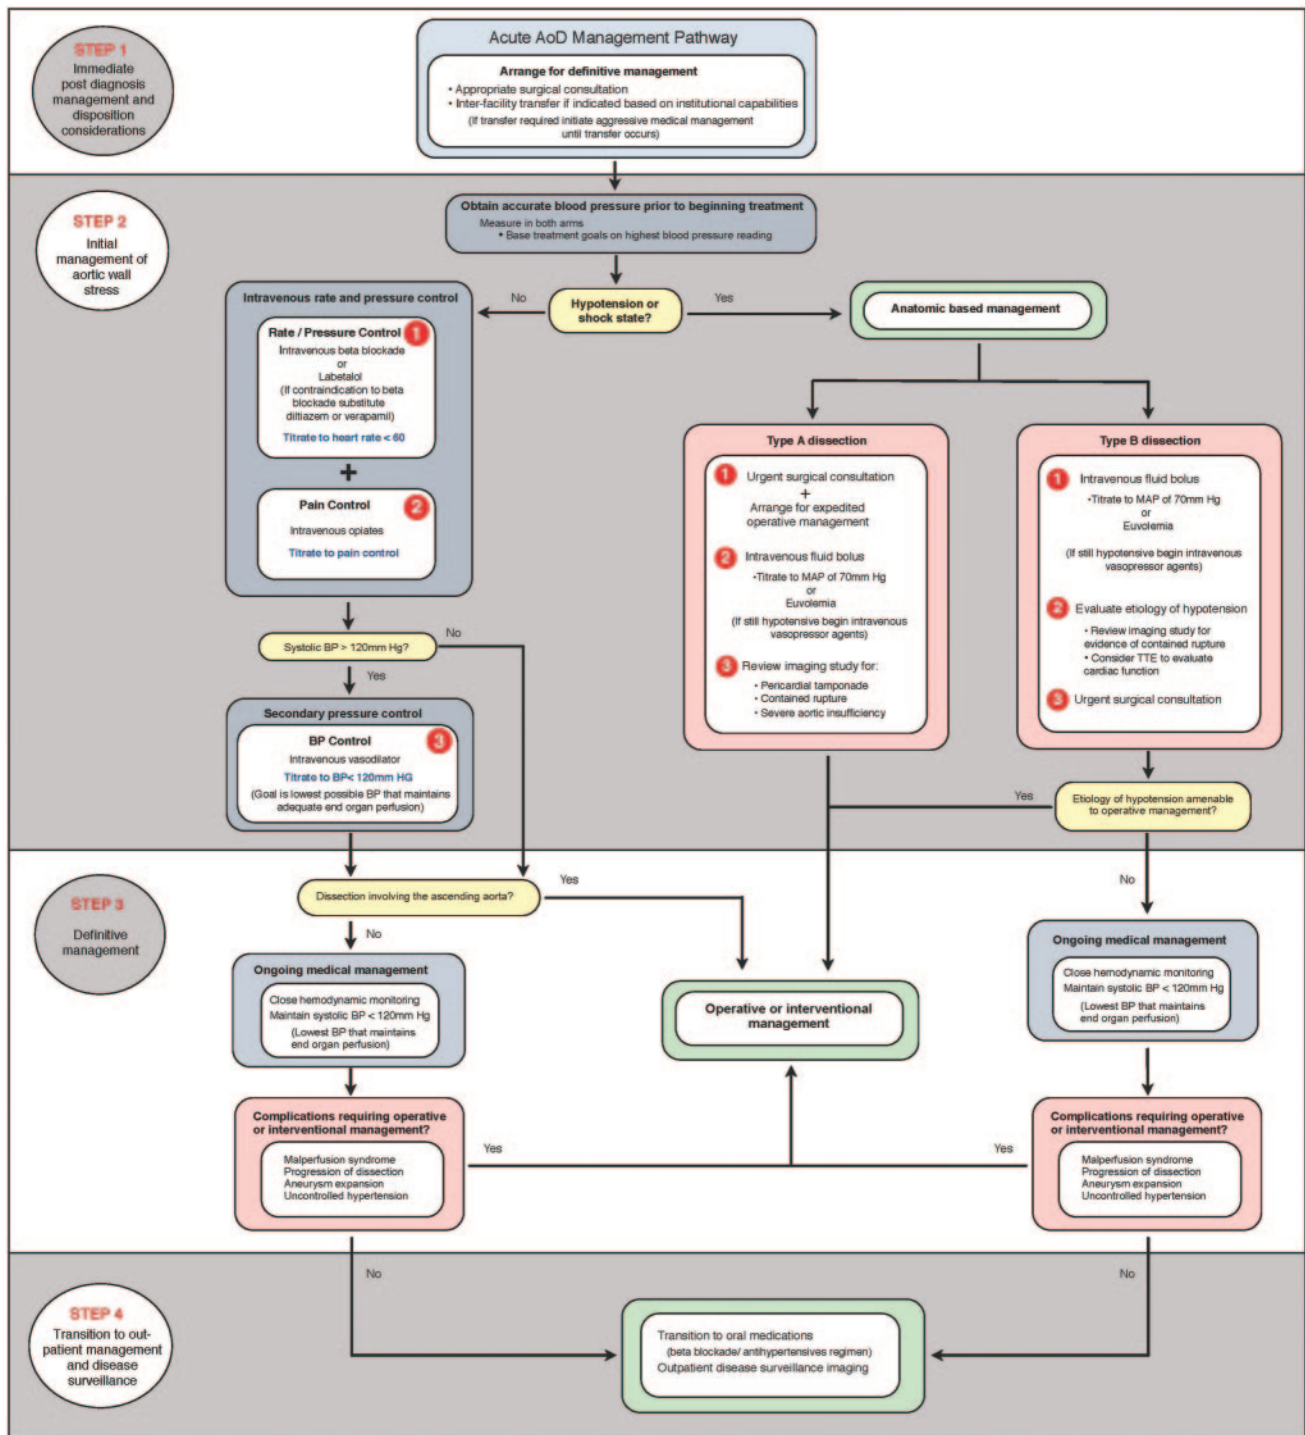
Acute AoD management pathway. AoD indicates aortic dissection; BP, blood pressure; MAP, mean arterial pressure; and TTE, transthoracic echocardiogram.
